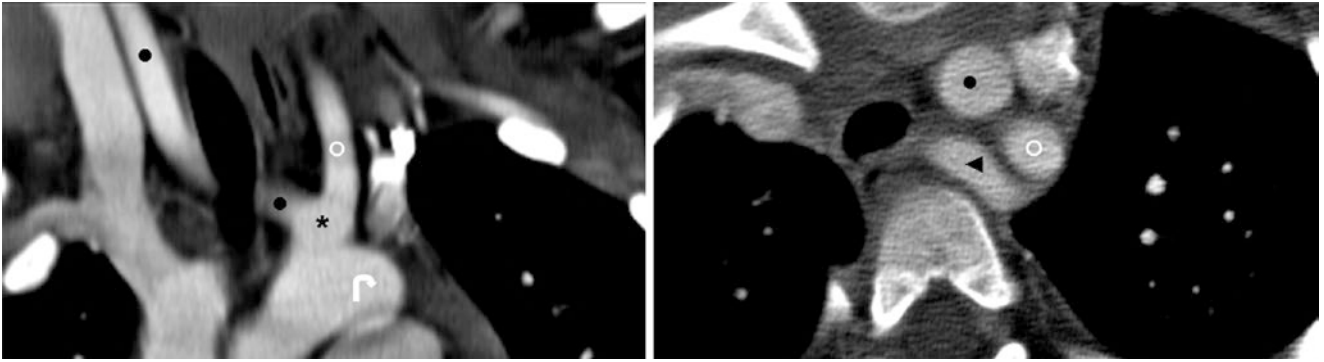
4-year-old with a chest contrast-enhanced CT in the coronal (*left*), and axial (*right*) planes, which demonstrate a left-sided aortic arch and a common origin (*i.e.*, "truncus bicaroticus," *asterisk*), along with a retroesophageal RSCA. *Aortic Arch* (*curved arrows*); *IA*
